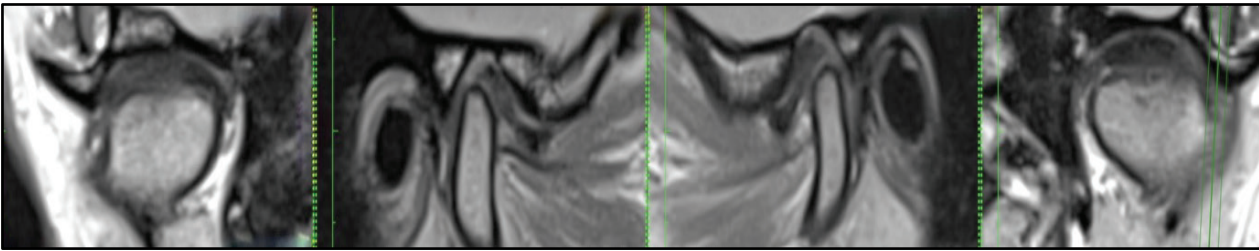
Results of the MRI examination of the TMJ (parasagittal and paracoronal projection of the medial pole, explanation in text)
